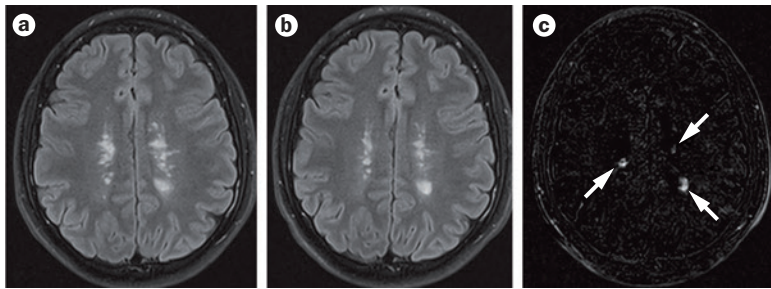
Subtraction MRI in a patient with relapsing–remitting multiple sclerosis. T2 fluid-attenuated inversion recovery (FLAIR) images a | at baseline and b | after 1 year. c | A subtraction of these two images highlights the new and enlarging lesions (arrows).
